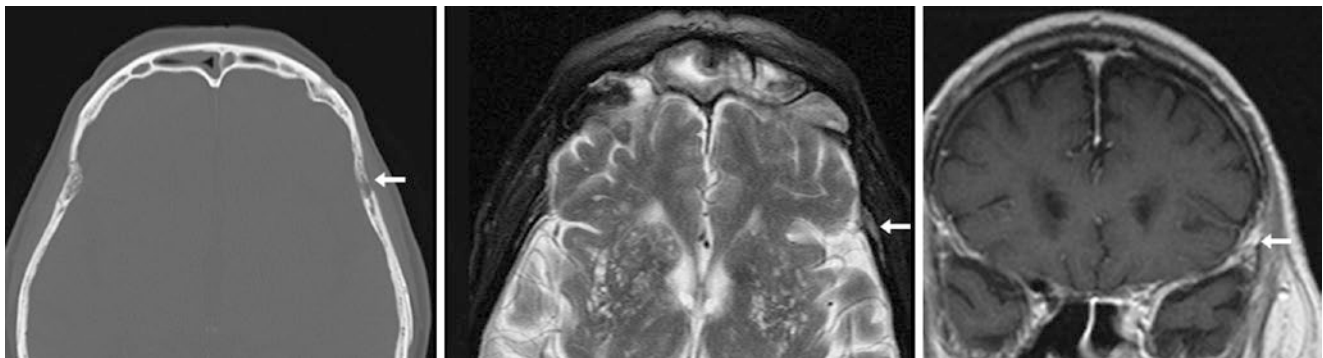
An 85 year old: a diploic vein on CT (left) was mildly isointense to gray matter on T2WI (middle) and exhibited mild enhancement on postcontrast T1WI (right). Also on T2WI the patient has cribriform-appearing basal ganglia from dilated perivascular spaces (*état criblé*)
